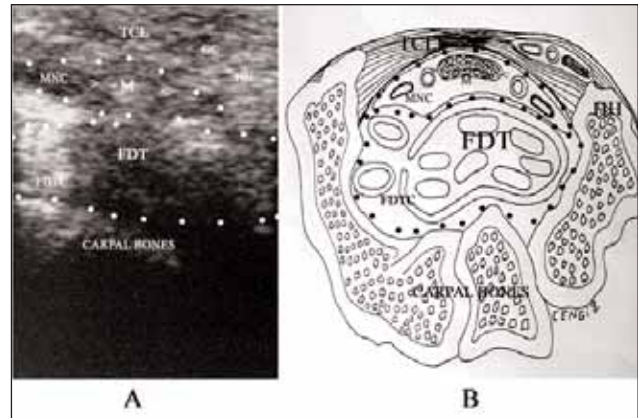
A. Ultrasonographic appearance of carpal tunnel in a normal subject (TCL: Transverse carpal ligament, GC: Guyon canal, HH: Hook of the hamate, MNC: Median nerve compartment, FTD: Flexor digitorum tendons, FDTC: Flexor digitorum tendons compartment, d
